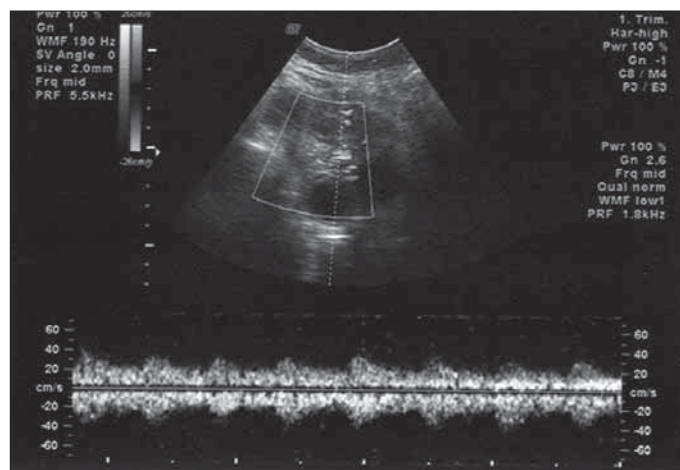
Detorsioned ovary with normal blood flow on Doppler US
